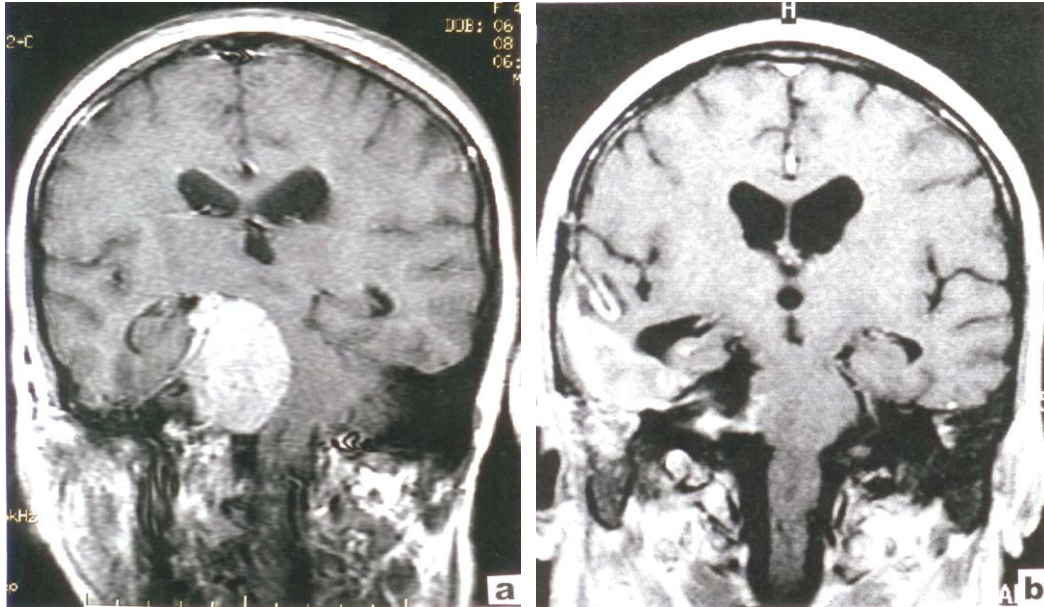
MRI studies of a petroclival meningioma (a) who compress from outside the brain stem provoke logorrhea syndrome with hyperkinezia. Postoperator (b) this syndrome disappear.
